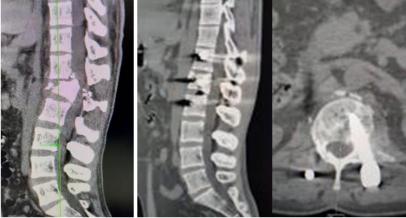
(Preop CT) Fig 2 (Postop CT)
